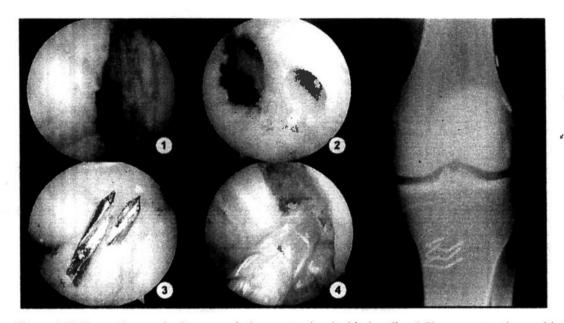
The arthroscopic images of the anatomic double-bundle ACL reconstruction, with postoperative radiograph: 1, ACL footprint of femoral side at 90° of knee flexion; 2, femoral tunnels at 110° of knee flexion, viewed from AM portal; 3, tibial tunnels created by inserting two guide pins with tibial jig at 55° and 45° for PL and AM bundles, respectively; 4, graft passage viewed from anterolateral portal. The postoperative radiograph shows the position of both the AM and PL tunnels in the distal femur and proximal tibia, with Endobutton fixation on the femoral side and bioabsorbable screws and bone staples on the tibial side.
